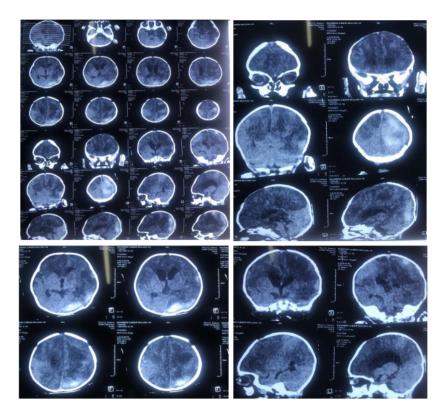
HEAD CT-SCAN WITH CONTRAST AFTER THERAPY.
